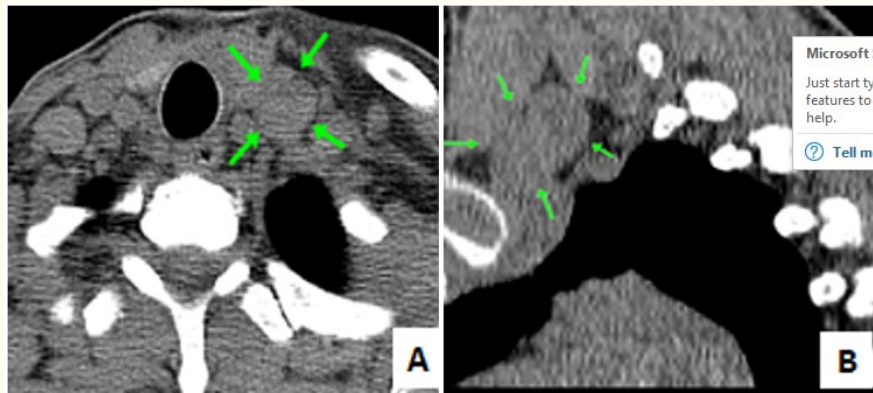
CT images in axial (A) and sagittal (B) sections passed by the cervical level showing a left inferior parathyroid mass (green arrow) with tissue density, oval, well limited, regular contours, measuring: 28 x 20 x 14 mm.
